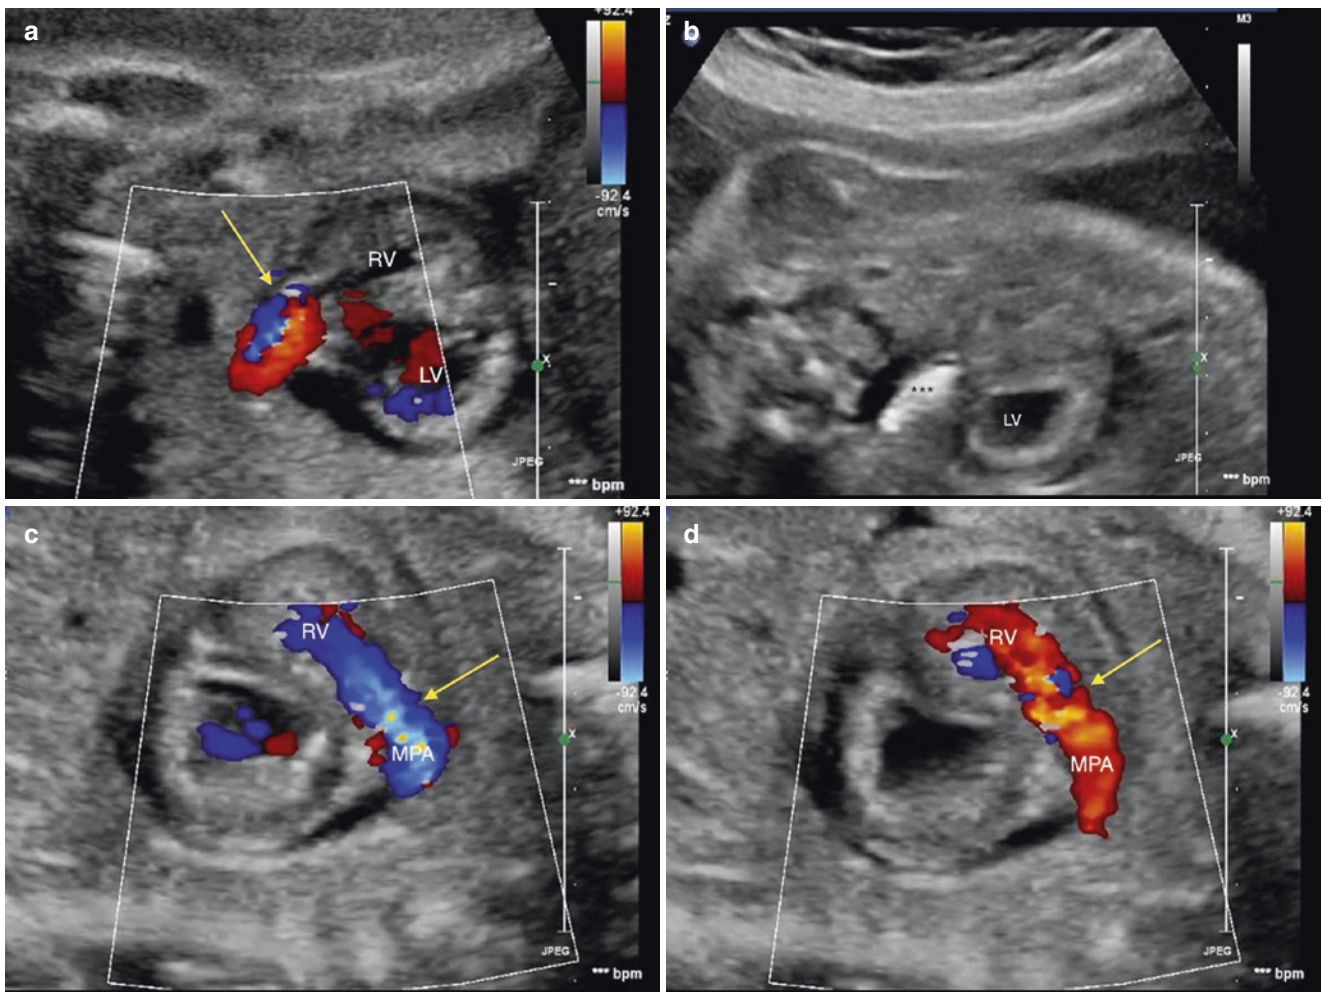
Critical pulmonary valve stenosis in a 28 weeks gestational age fetus. (a) Echocardiographic evaluation before intervention. There is a tiny forward flow (in blue color) across the pulmonary valve (indicated by an arrow) as shown by color flow mapping. Retrograde flow across the ductus is depicted by red color on color flow mapping. The pulmonary valve annulus measured 4.0 mm. (b) A 10-mm-long coronary balloon (marked with black asterisks) is inflated across the pulmonary valve up to the burst pressure reaching 4.7 mm in diameter.
